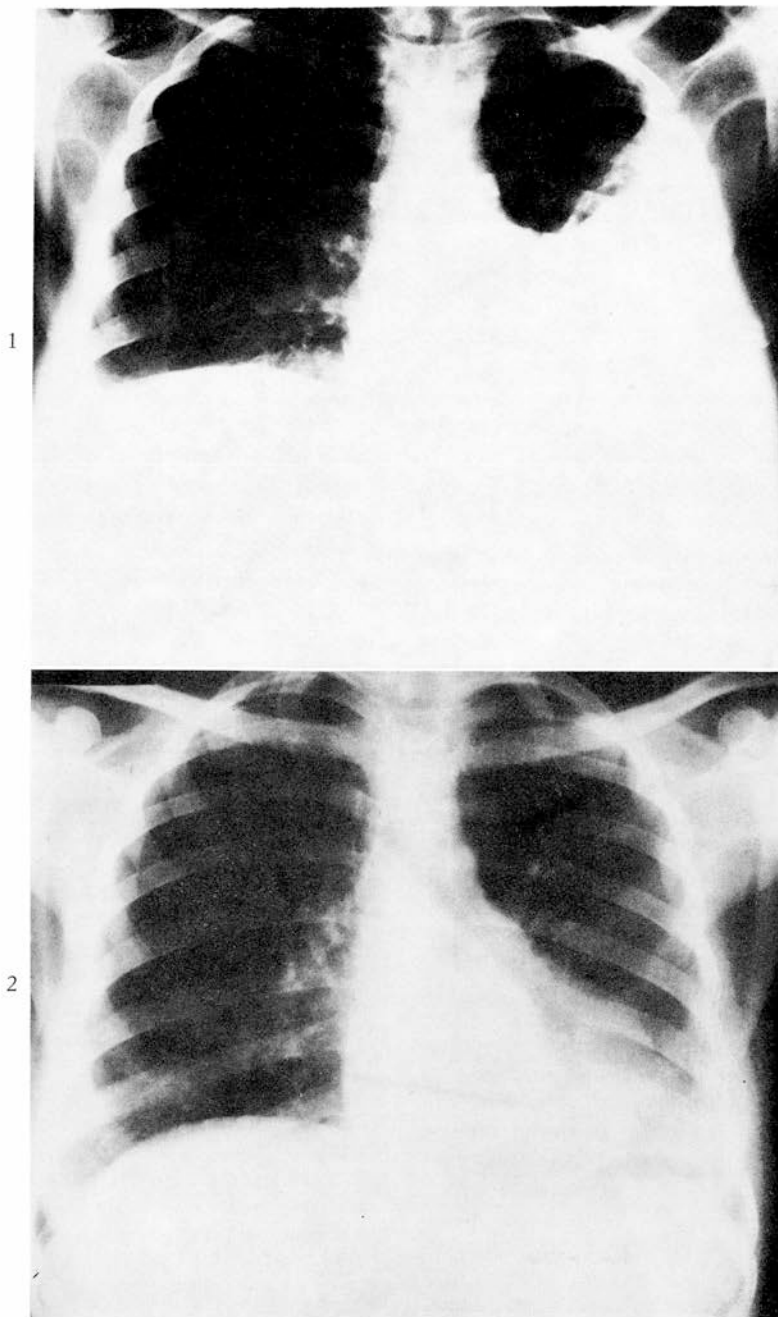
Chest X-ray demonstrating pleural effusion prior to surgery.
